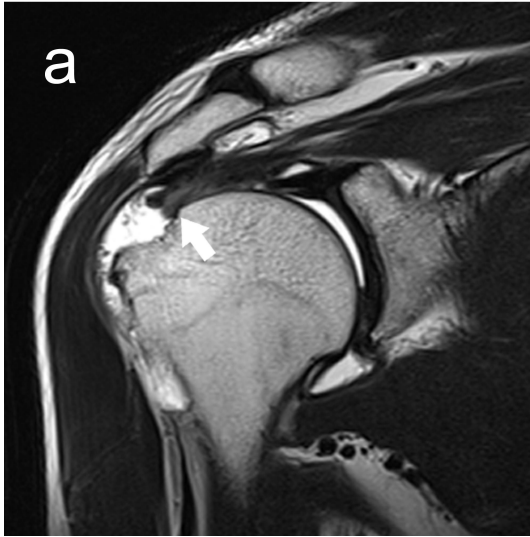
53-year-old man with traumatic rotator cuff tear. Torn tendon with blunt edge (white arrow) on the T2-weighted oblique coronal image.
